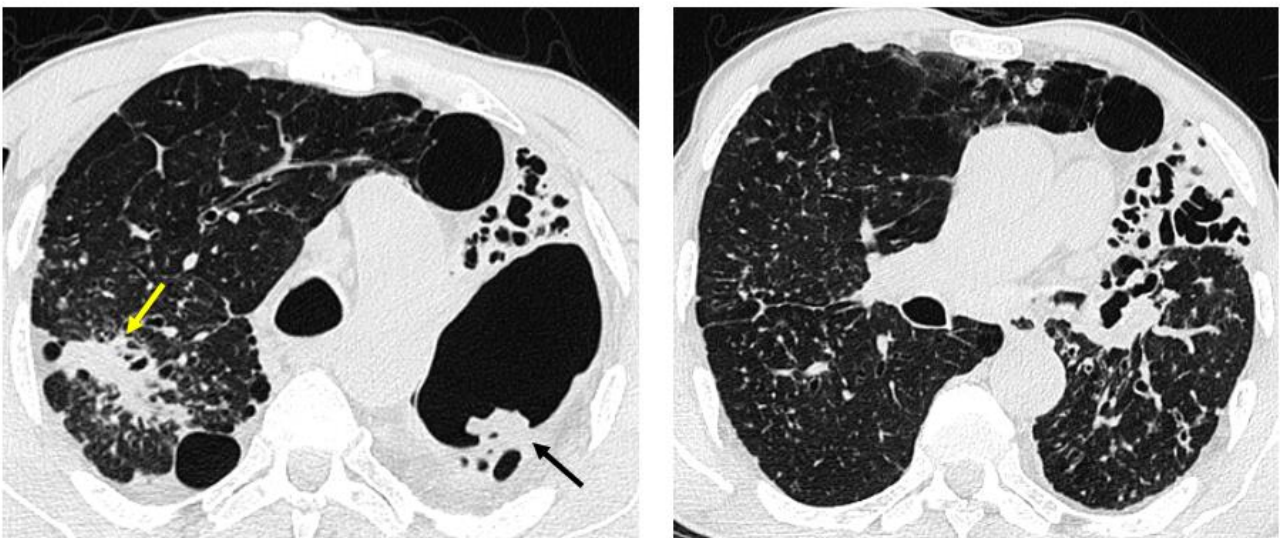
a 70 year-old men with silicotuberculosis. CT shows fibrotic mass of the right upper lobe (yellow arrow) with bilateral perilymphatic micronodules. Sequels of TB are obvious in the left upper lobe with aspergilloma development (black arrow)
